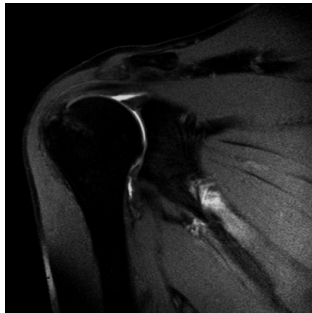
Coronal T1-weighted image showing intact tendon after single row repair.
